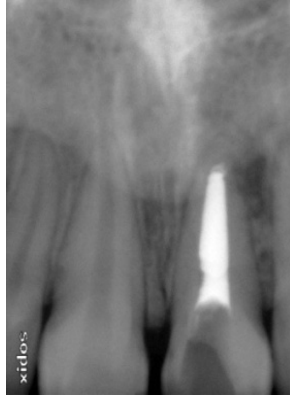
At the end of 6 months there was evidence of closure of foraminal opening, reduction of periapical radiolucency associated with 2mm of additional root development.
